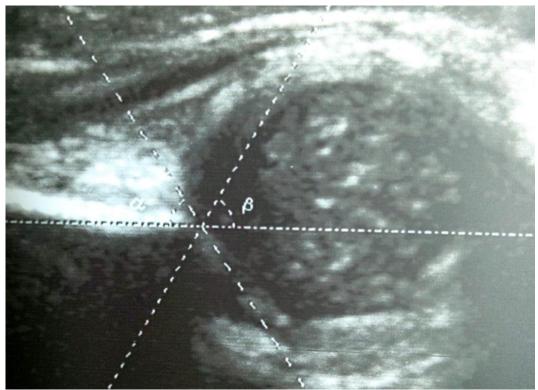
3.8 An ultrasound image from the current of a 10 day-old-boy showing Graf type lla- hip with alpha angle 50 and beta angle 65 (Pathological Immature Hip).
